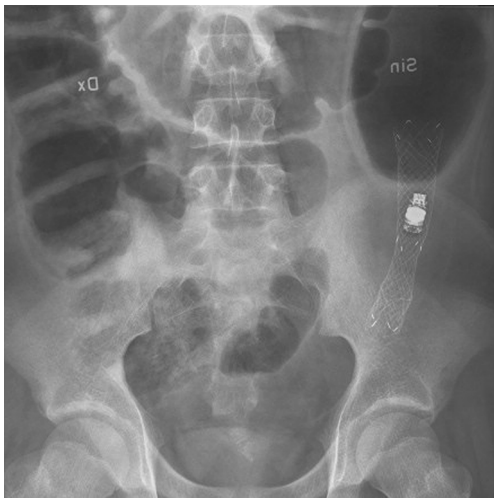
Appearance of the stent immediately after stenting visualized by use of plain abdominal X-ray.
